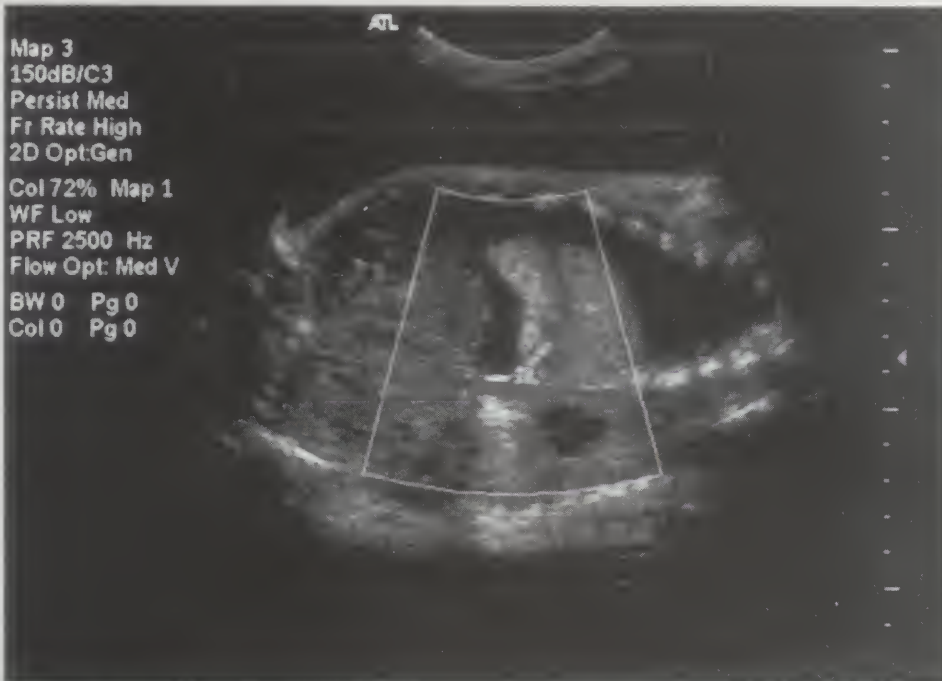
Sagittal section of the fetal chest using color Doppler examination and demonstrating a vessel connecting the mass to the descending aorta.
